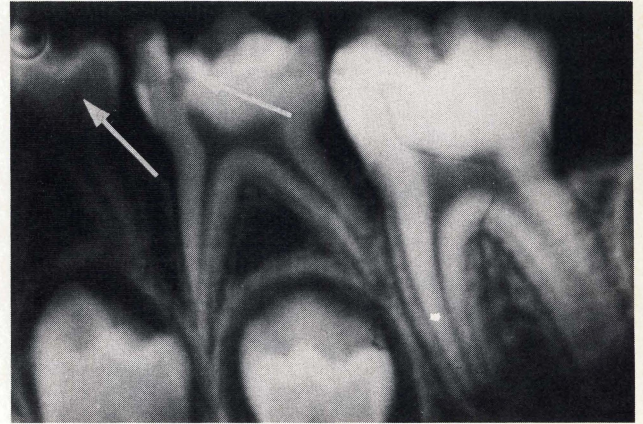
An apical radiograph of the mandibular left first primary molar and the mandibular left secondary primary molar indicating crown fracture lines only.
